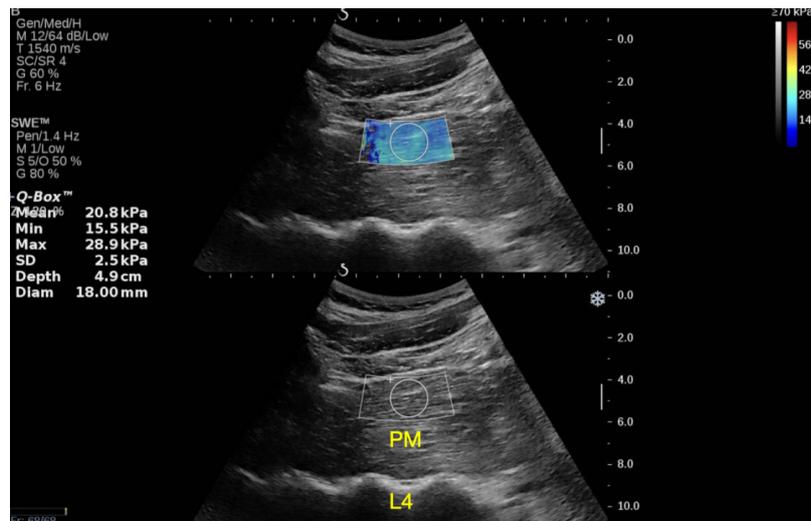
1 Anatomical adjacencies and ultrasound shear wave elastography measurement of psoas major (PM)
